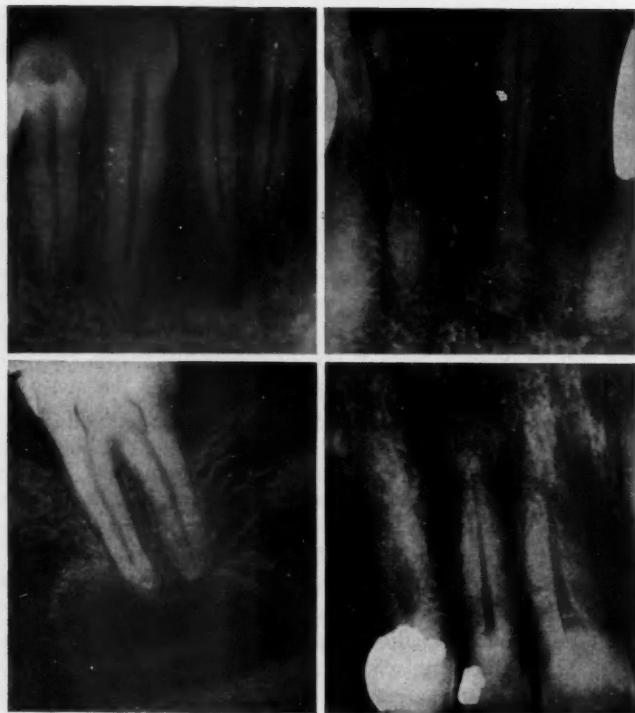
The periapical abnormalities of these four cases are due to cementomas in different development stages. The teeth are vital.
